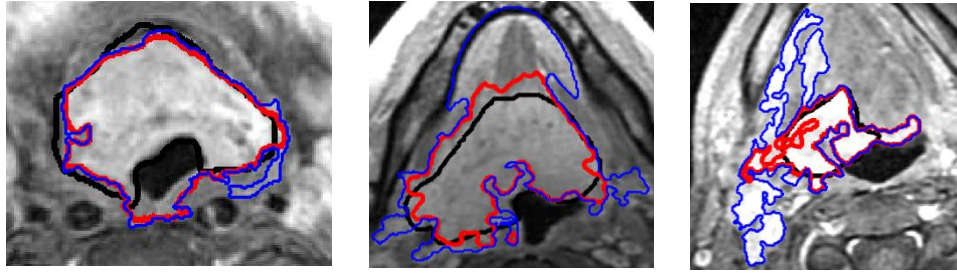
Tumour extraction results on real MRI slices (black outline: reference (manual), red: MFCM, blue: standard FCM). MFCM clustering extracted results close to manual outline compared to standard FCM clustering.
